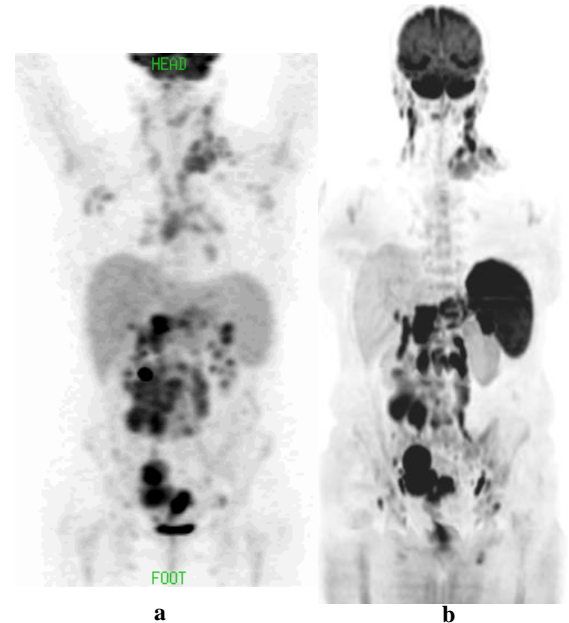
A 65 year old women with a non-Hodgkinian malignant lymphoma who was treated but referred back for suspicion of recurrence. (a) 18F-FDG uptake image (b) DWI images MIP with reversed gray scale display. The patient presented a diffuse recurrence.
